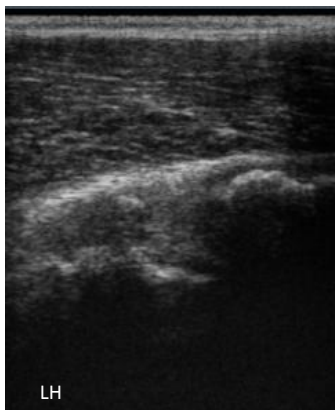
&5 Longitudinal ultrasonograms of the left hind proximal lateral femur (distal to the left) demonstrating considerable periosteal roughening indicating callous formation.
